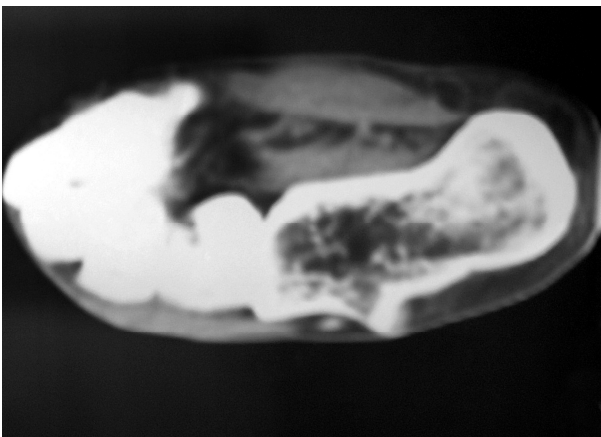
CT images of protuberant peroneal tubercle.
